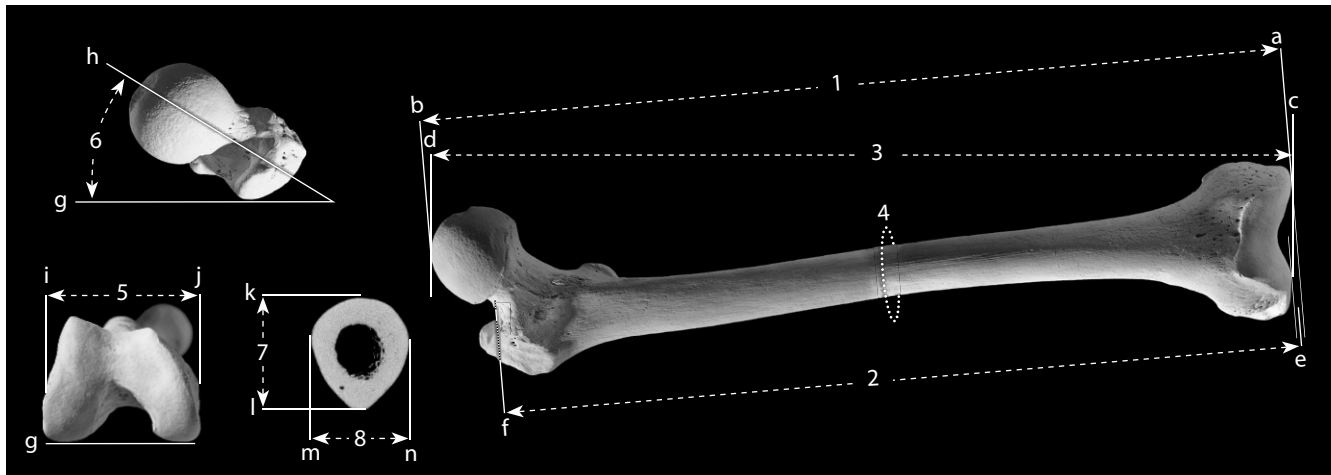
Femoral measurements. One-fourth (bone) and one-half (CT scan) natural size.
